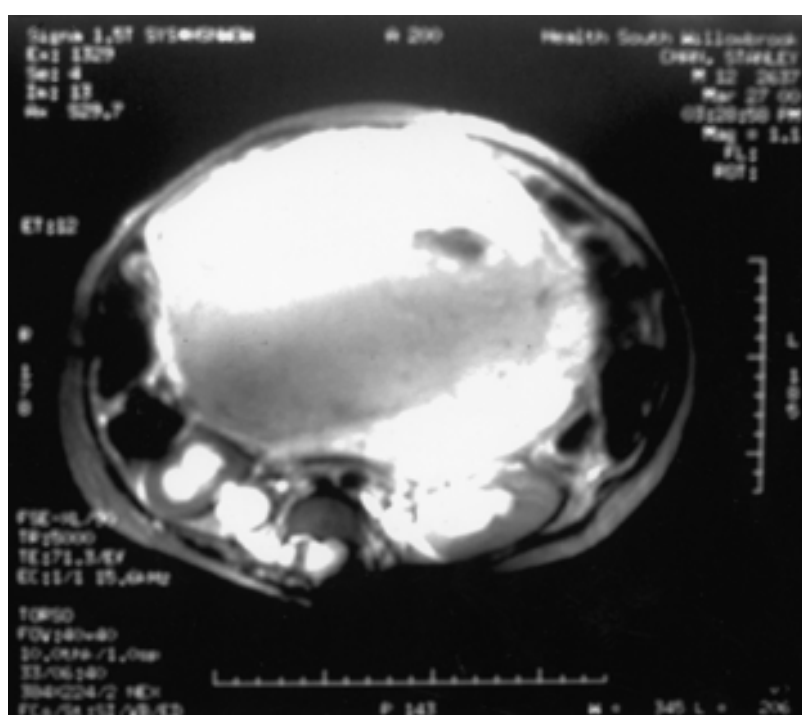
Computed tomography scan of a large prostatic rhabdomyosarcoma extending into the upper abdomen with bilateral hydronephrosis.
